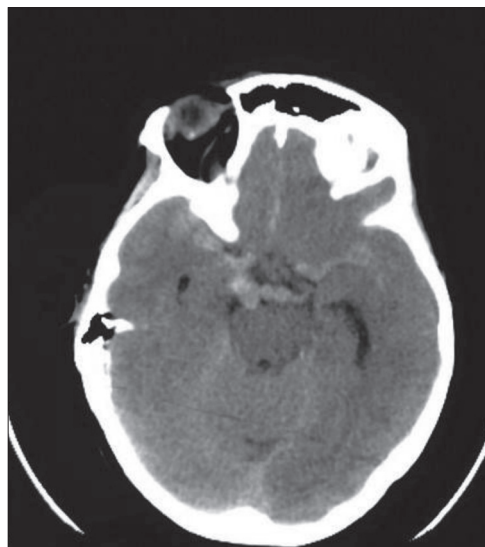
Initial brain computed tomography scan demonstrates diffuse subarachnoid hemorrhage and aneurysm-like formation in front of the pons
